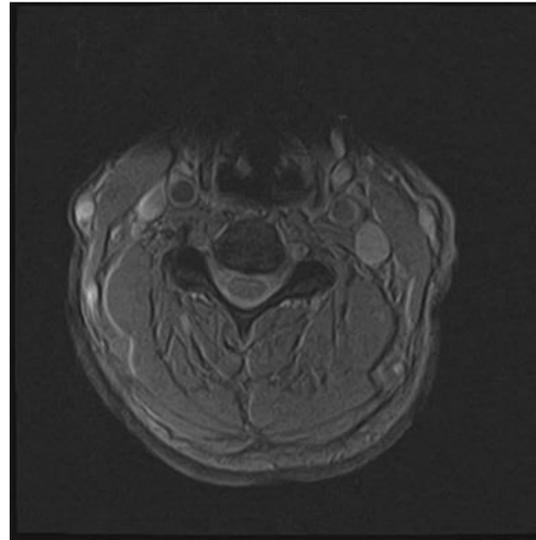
Axial T2-weighted MRI C-Spine showing intraspinal haematoma at C5/6
